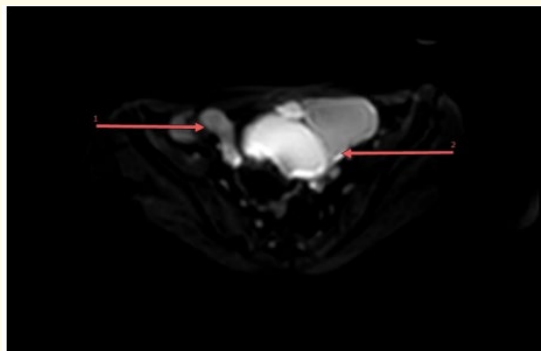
Pelvic MRI, axial DWI sequence, showing the ovary which is hyperintense, separated from the mass, confirming the extra ovarian origin of the tumor.
